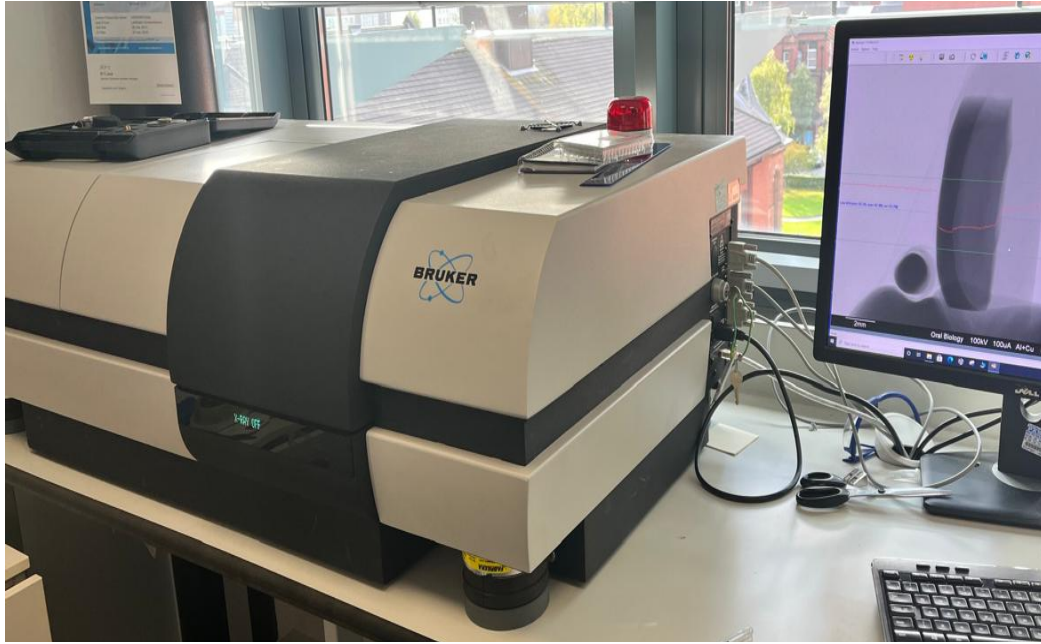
Microcomputed Tomography
